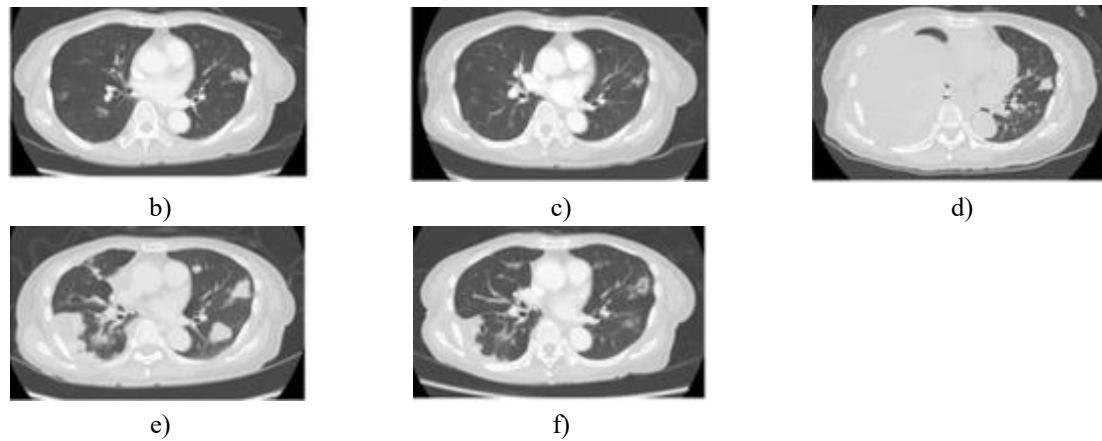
Treatment trajectory and imaging of a patient undergoing HER2-targeted therapy. (a) Changes in tumor markers, including CEA and CA 19-9, over the course of therapy. (b–f) Contrast-enhanced CT images documenting treatment response. At the initiation of trastuzumab/pertuzumab, multiple metastatic lesions were present in the lungs and liver (liver lesions not shown) (b). After two months, a notable partial response was observed (c). By nine months, disease progression manifested as a large right pleural effusion (d). Following pleurodesis (e), therapy was switched to trastuzumab deruxtecan, resulting in tumor reduction within six weeks (f).
